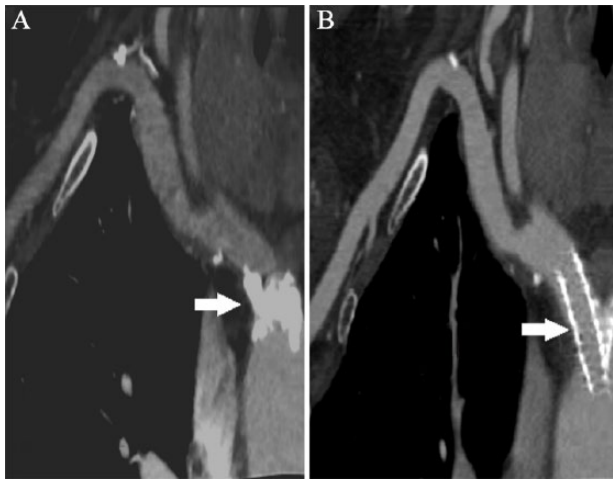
Computed tomography examination showing: (A) critical calcified plaque of Innominate artery; (B) patency of the Innominate artery after stenting.
